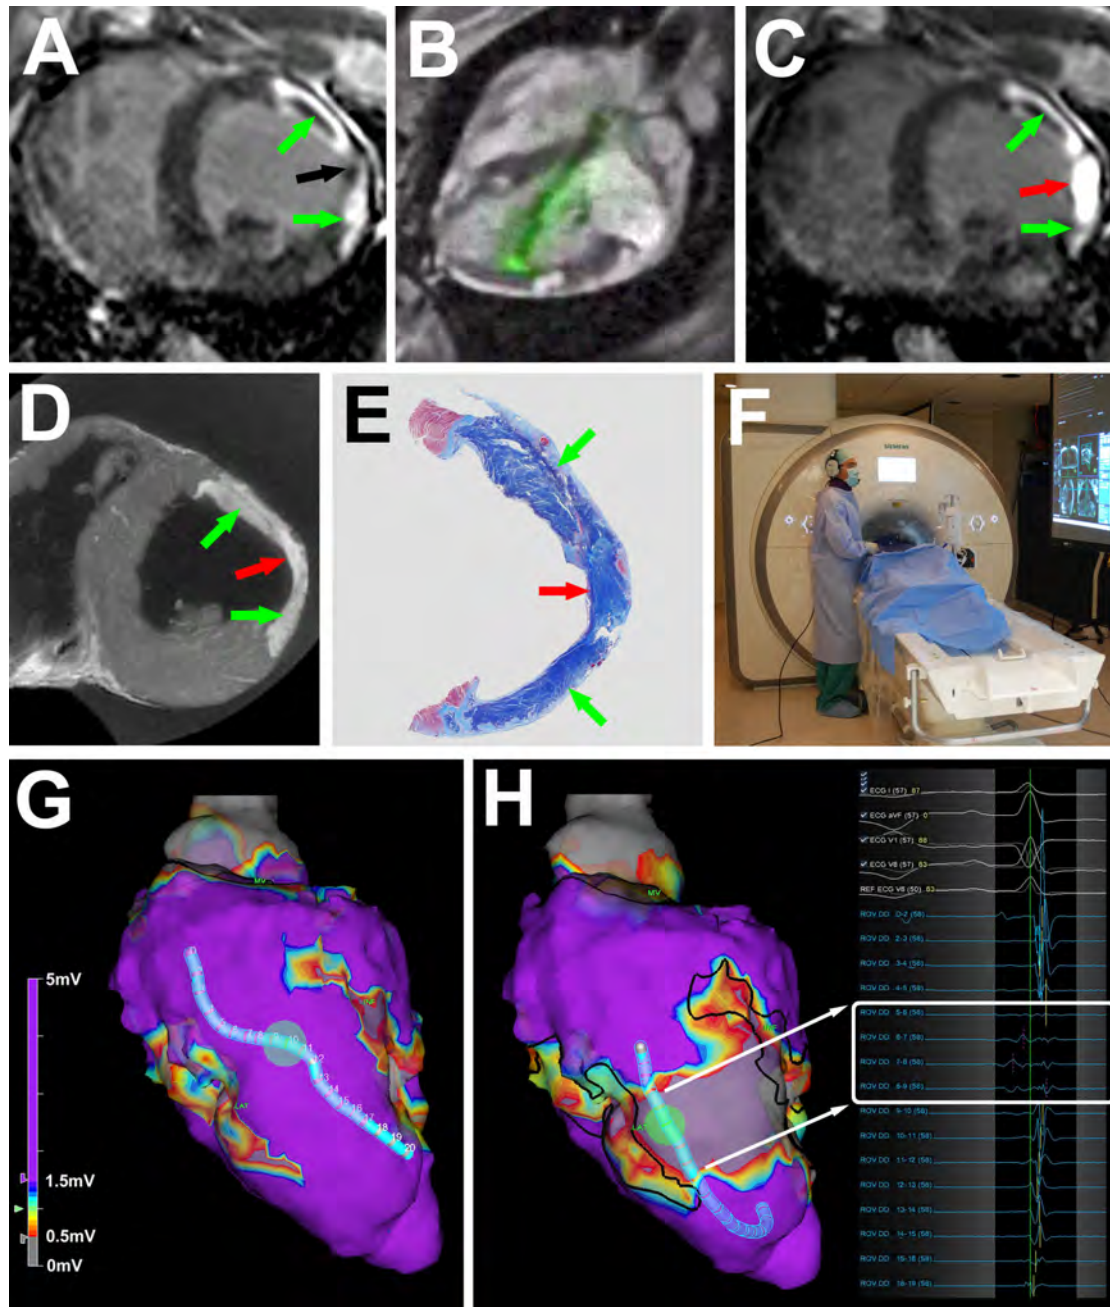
MRI guided chemoablation of a conductive isthmus
